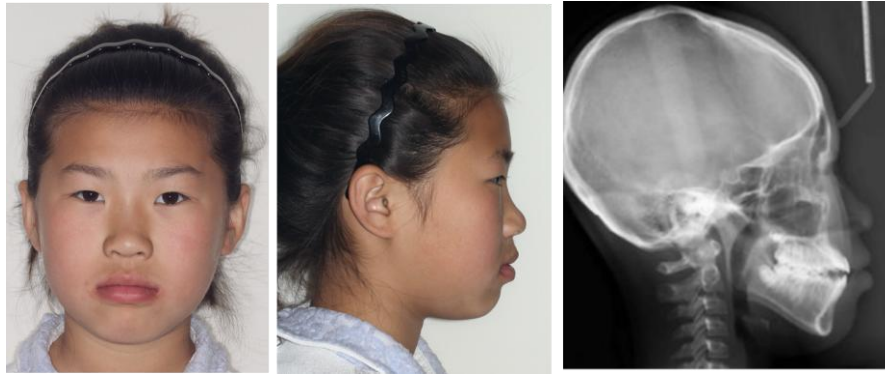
Stage 1 finished (extraoral and radiography): (A) Front view; (B) Profile view; (C) cephalometric.
